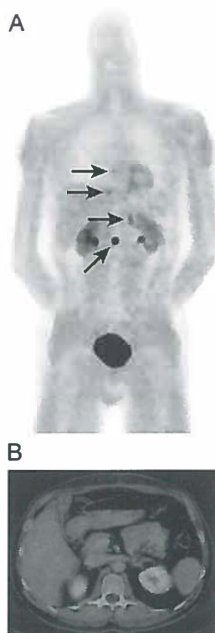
Imaging of a patient with a known metastatic pheochromocytoma. (A) ¹⁸F-DOPA PET shows increased uptake in the left adrenal gland and three lesions in the spine (arrows). (B) Fusion image of ¹⁸F-DOPA PET and CT shows uptake in the region of the left adrenal gland, without anatomical substrate. (C) CT image of the region of the left adrenal gland. ¹²³I-MIBG imaging was negative (not shown).
